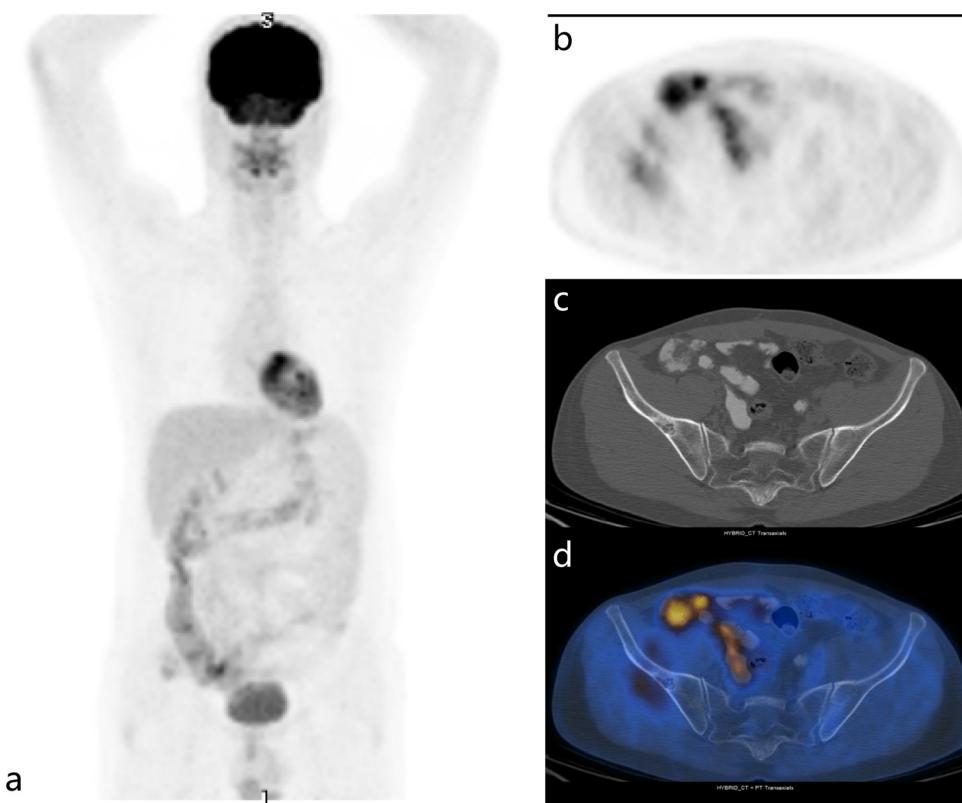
FDG PET-CT images after SABR, showed disappearance of FDG uptake in the solitary osteolytic lesion in right iliac bone with increased sclerosis compatible with therapy response (a: Maximum intensity projection images (MIP), b-d: FDG PET, CT and fusion images). Mild reactive-inflammatory FDG uptake in peri-lesional muscle was also noted.
